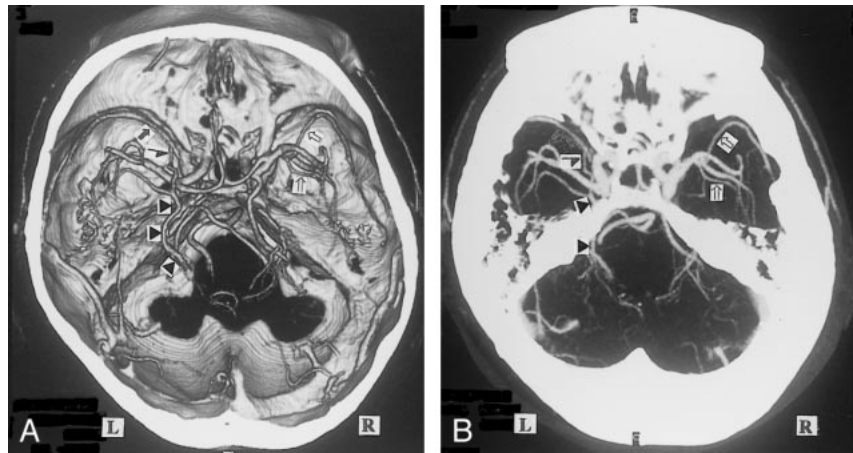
A, 3D CT angiogram (axial view) and B, posteroanterior stereoscopic views. The right anterior cerebral vein (↑) and the deep middle cerebral vein (⇒) enter the sphenoparietal sinus via the uncal vein (†) without forming the anastomosis between the first and second segment, and also communicate through the peduncular vein (≫) with the contralateral BVR and the anterior pontomesencephalic vein (>). The left BVR communicates via the uncal vein (†) with the cavernous sinus, via the deep middle cerebral vein with the insular vein (⌞) and the superficial middle cerebral vein (‡), via the peduncular vein (≫) with the anterior pontomesencephalic vein (>), and the great vein of Galen posteriorly.
